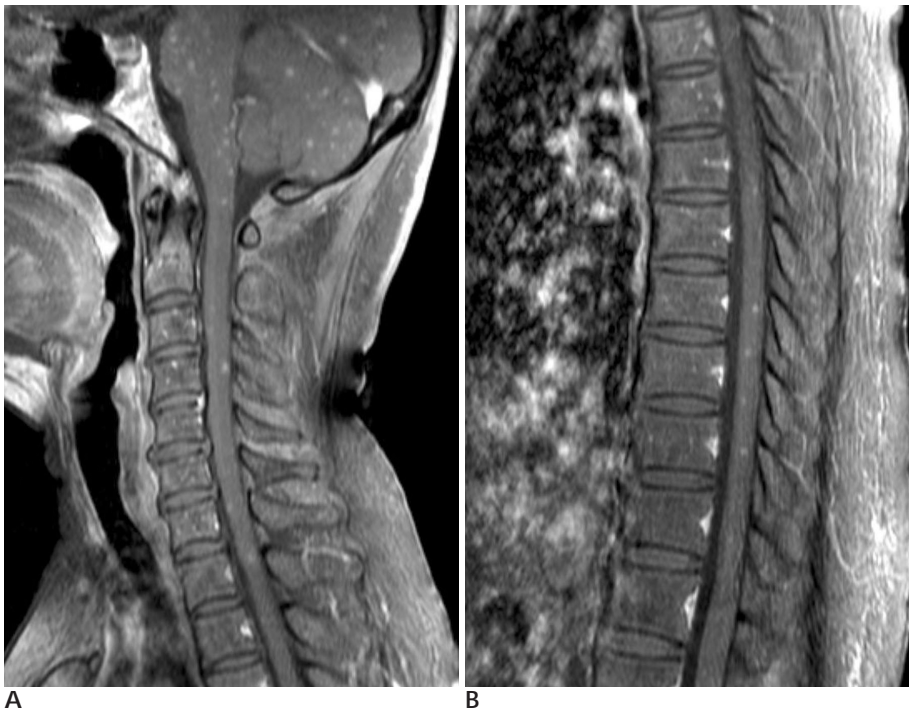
Contrast enhanced sagittal T1-weighted spine MR scans show about 4 mm or less sized multiple enhancing nodules in the cervical (A) and thoracic spinal cord (B).
